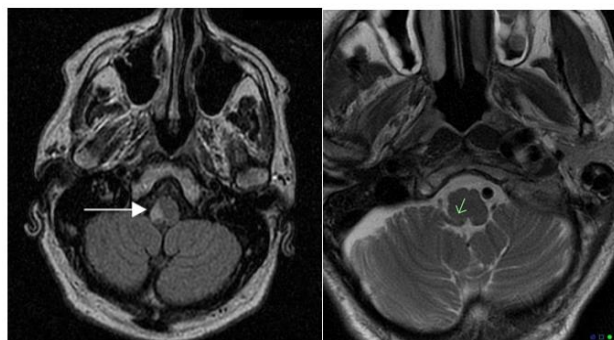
Axial FLAIR picture demonstrating a high signal focus consistent with an infarct in the dorsolateral part of the right side of the medulla oblongata (arrow).¹⁹
